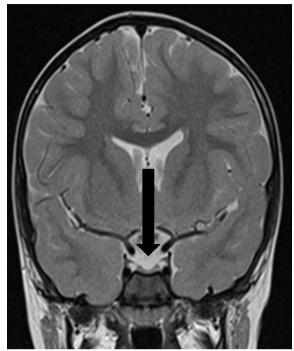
Coronal T2-weighted image showing small anterior pituitary measuring 1 mm in height (black arrow)
